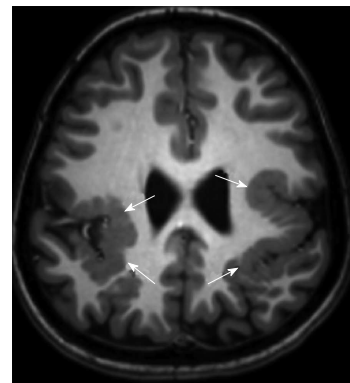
A 7-year-old boy with polymicrogyria. Axial 3D T1-weighted image shows bilateral perisylvian polymicrogyria (arrows).
